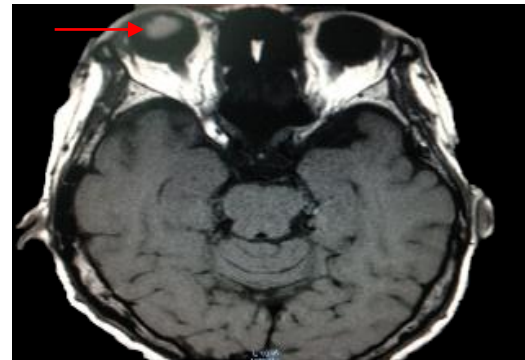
Magnetic resonance imaging showed an intraocular lesion (arrow).
